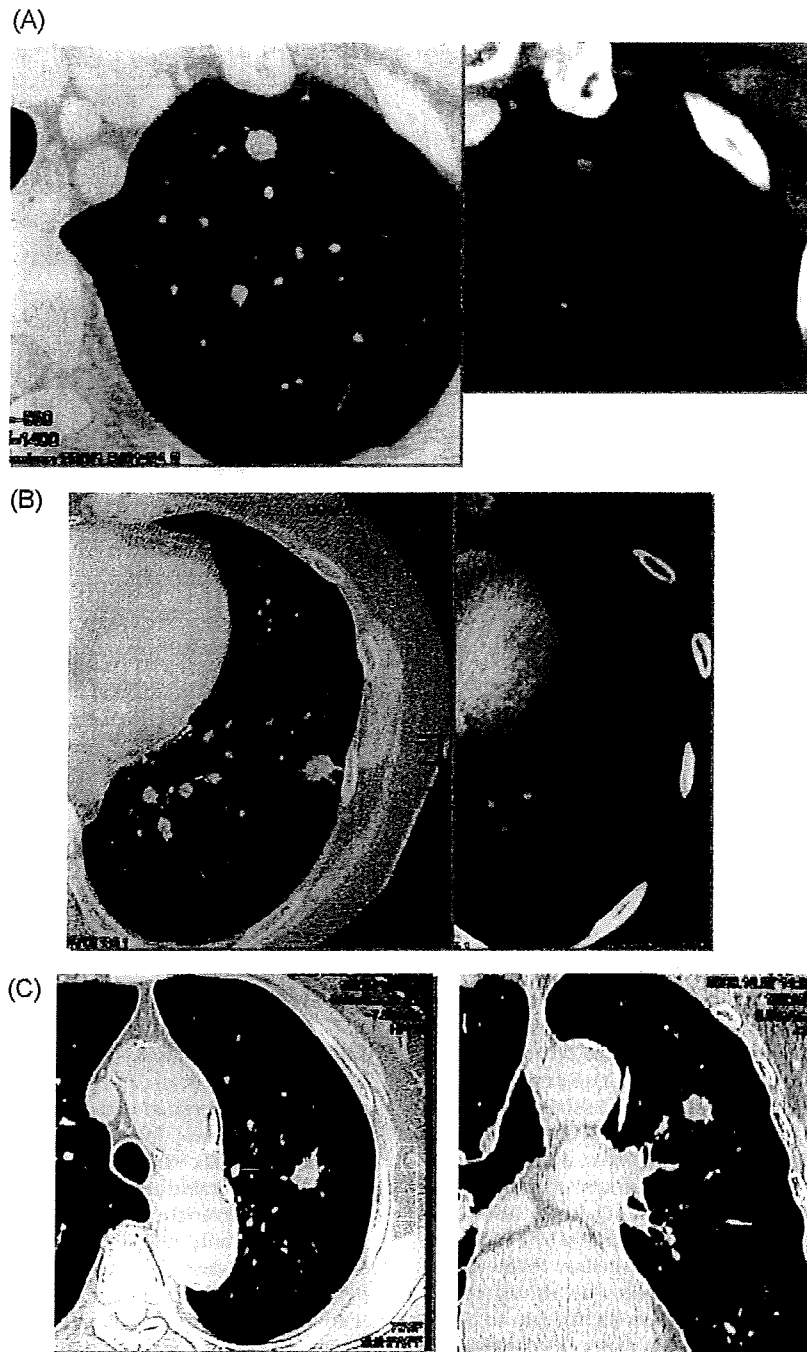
Computed tomography (CT) from three representative patients with mediastinal lymph node metastasis. (A) CT images from a 55-year-old man. (B) CT images from a 53-year-old woman. (C) CT images from a 76-year-old woman. All three tumors showed a solid pattern without GGO on CT.
